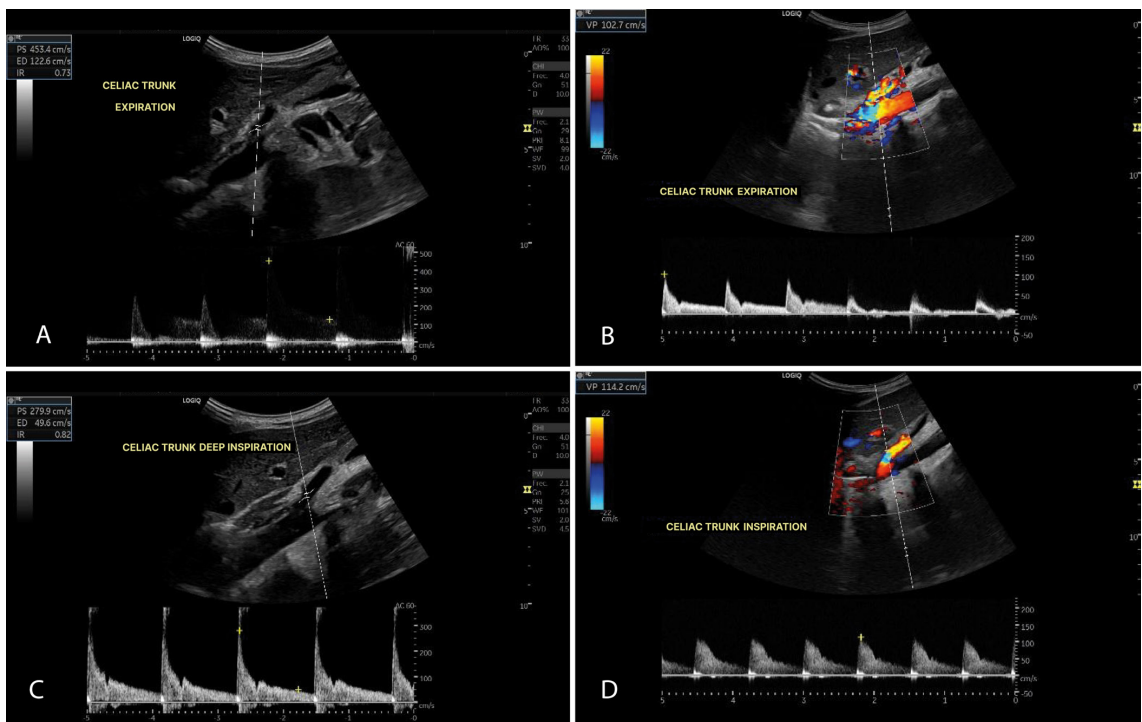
Doppler ultrasonography of the celiac trunk before and after surgical intervention during inspiration and expiration. (A) Preoperative Doppler ultrasonography of the celiac trunk during expiration; (B) Postoperative Doppler ultrasonography of the celiac trunk during expiration; (C) Preoperative Doppler ultrasonography of the celiac trunk during deep inspiration; (D) Postoperative Doppler ultrasonography of the celiac trunk during deep inspiration.
